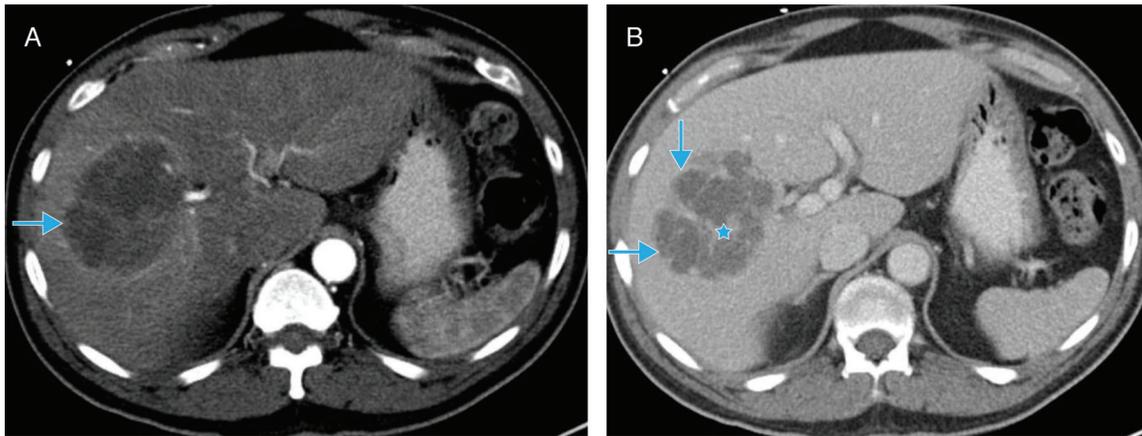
Dynamic contrast-enhanced computed tomography (CT). A. Late arterial phase CT demonstrates hypervascular, peripheral enhancement of the abscess seen in Figure 4 (blue arrow). B. Portal venous phase CT demonstrates conspicuity of internally enhancing septations (blue star), likely representing intervening hepatic parenchyma. Note the multilocular nature of the abscess, which has implications for potential treatments (blue arrows).
